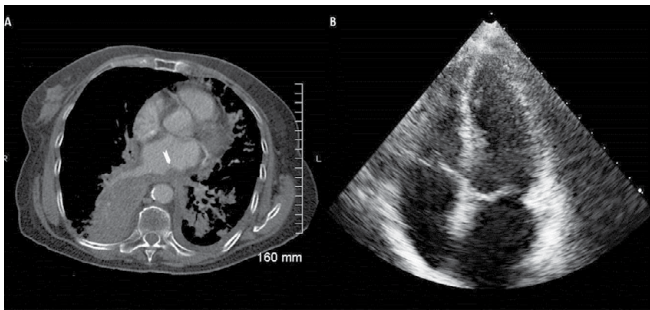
and 3B (3A) CT chest, transverse section showing post radiation changes and significant reduction in the intra cardiac mass (arrow head); (3B) Four chamber echocardiogram showing the left atrium without a visible mass.
